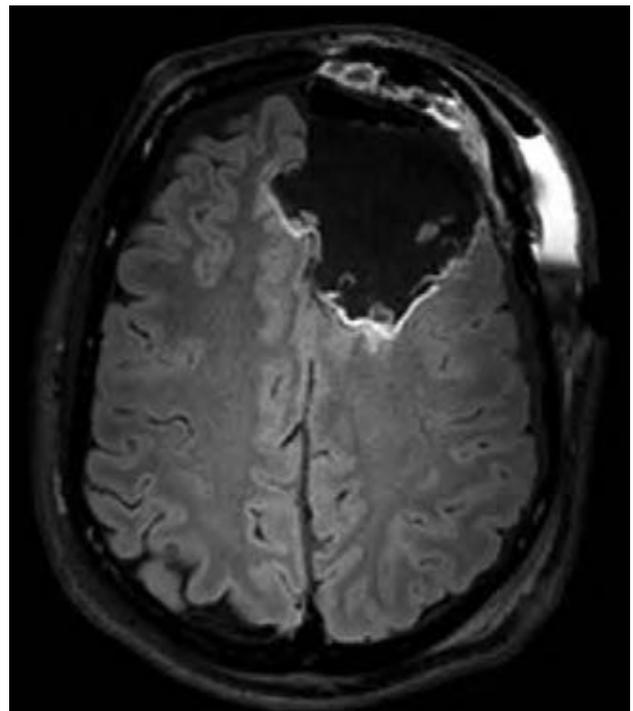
T2-fluid-attenuated inversion recovery (FLAIR) magnetic resonance imaging showed a tumor recurrence in the posterior and medial walls of the surgical site.
